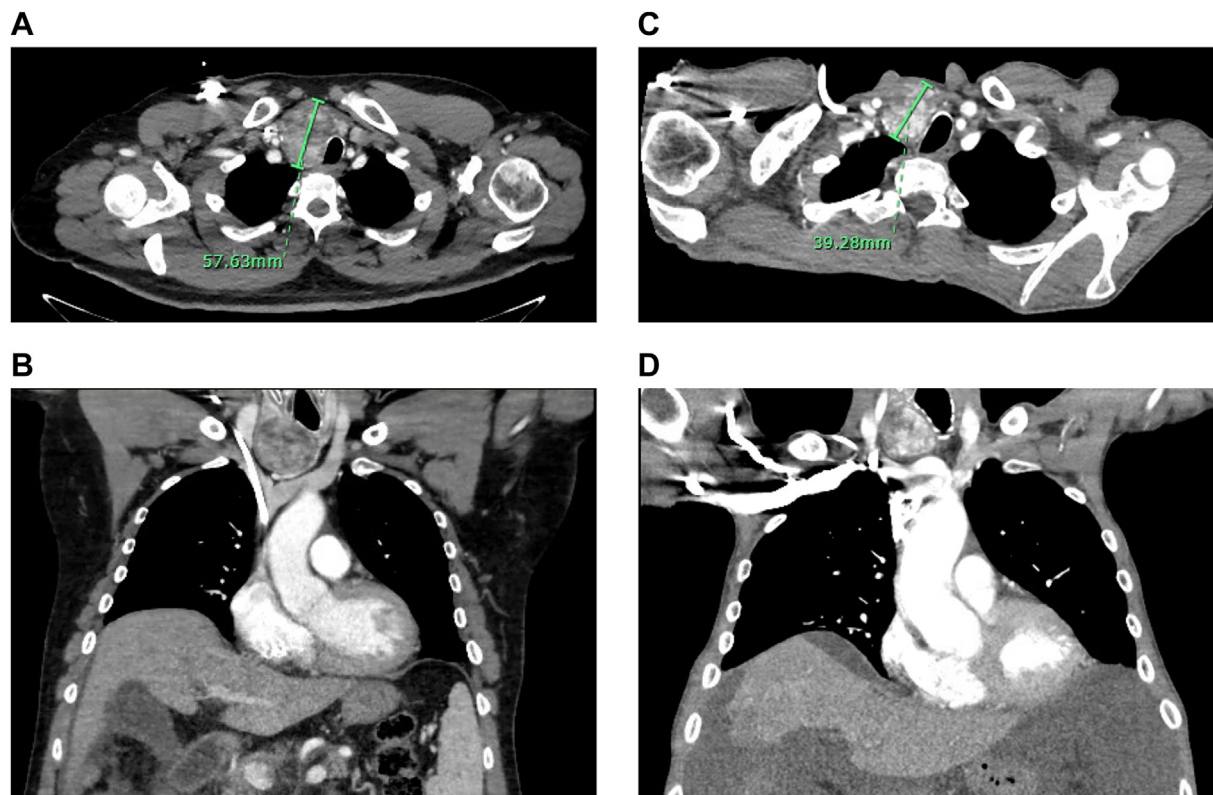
Regression of papillary thyroid carcinoma (PTC) after initiation of immune checkpoint inhibitor (CPI) therapy and occurrence of CPI-induced thyroiditis. Contrast-enhanced computed tomography imaging of the neck and chest in transverse (A) and coronal (B) planes revealed the pretreatment tumor size of a fine needle aspiration biopsy–proven PTC of $4.1 \times 5.8 \times 4.7$ cm. The patient subsequently developed CPI-induced thyroiditis and resultant hypothyroidism. At the last follow-up, 12 months after CPI-induced thyroiditis, similar transverse (C) and coronal (D) computed tomography images showed a significant reduction in the tumor size to $2.9 \times 3.9 \times 3.2$ cm, representing a 60.7% decrease in the tumor volume.
